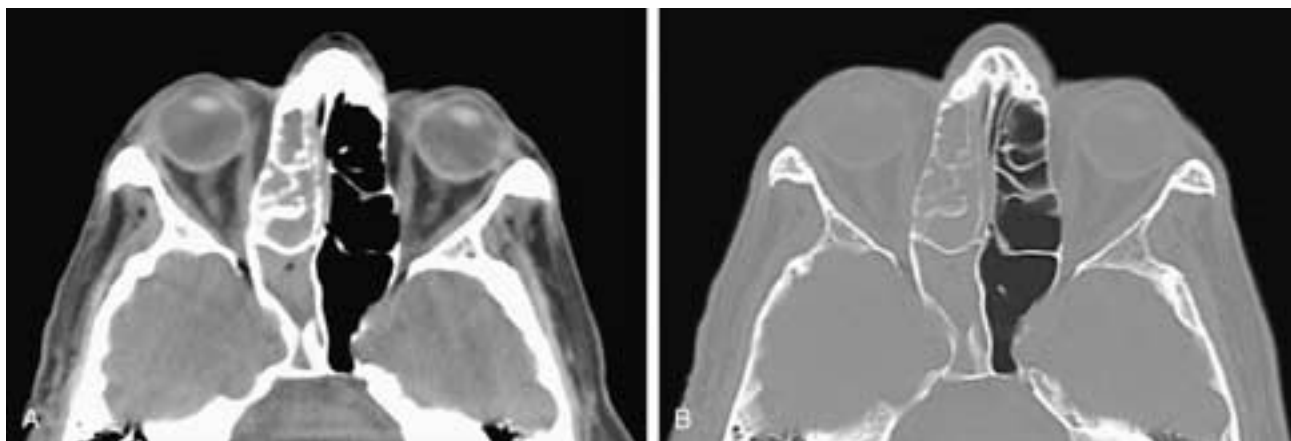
Axial CT scan (A) shows opacification of the right ethmoid and sphenoid sinuses. The ethmoid septae and the surrounding bone appear thickened and sclerotic on this narrow “soft-tissue” windowed image. This might imply a chronic process. However, in B, the same image viewed at wide “bone” window settings, the bone appears normal and similar to that on the left side. This is the more accurate assessment of the bone size and density in this patient with clinically acute sinusitis.
